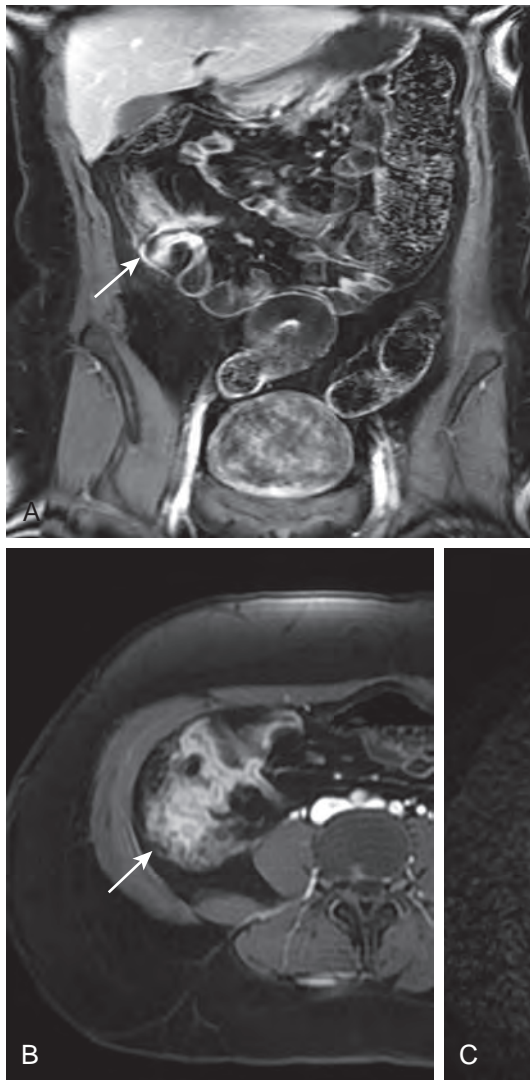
Crohn's disease recurrence (same patient as in Fig. 6-5). On a follow-up MR examination in 2012, the coronal (A) and axial (B) 3D GE gadolinium-enhanced images show interval recurrence of the right lower quadrant inflammatory changes (arrows). (C) A DWI, B value of 500 s/m², shows recurrence of the restricted diffusion (arrow) in the right lower quadrant.
